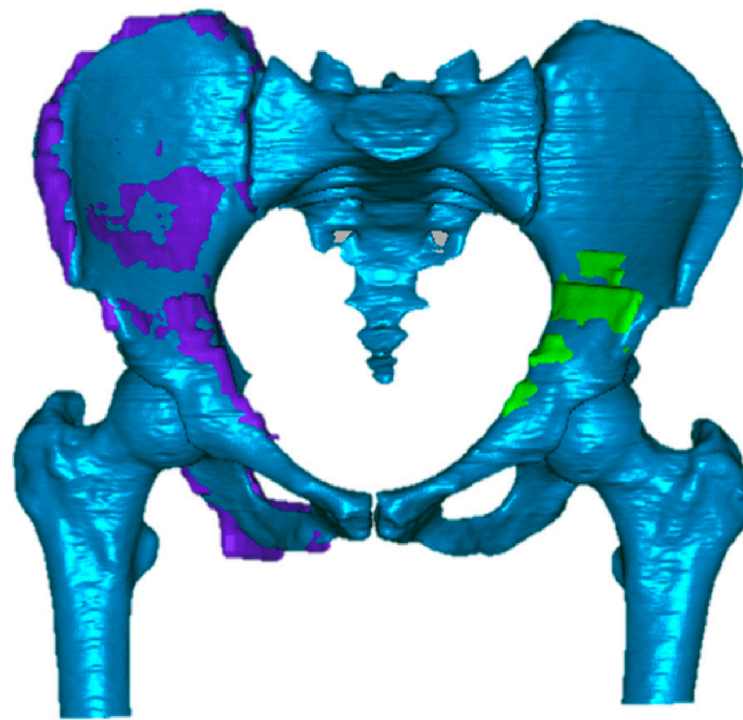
The 3D result after a best-fit registration of the MRI-based models to CT-based models; again, the model of the tumor from MRI is depicted in green.
